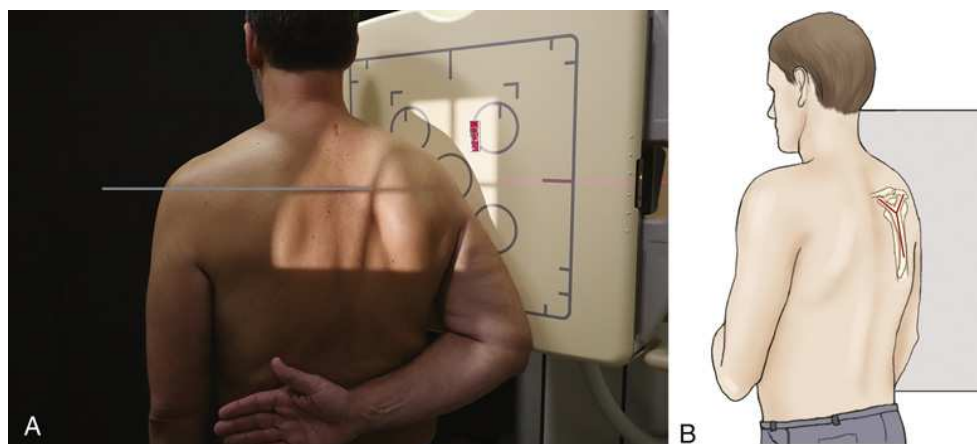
(A) Lateral scapula, RAO body position. Arm is positioned to demonstrate the acromion and coracoid process. (B) Perspective from x-ray tube showing scapula centered in true lateral position.
